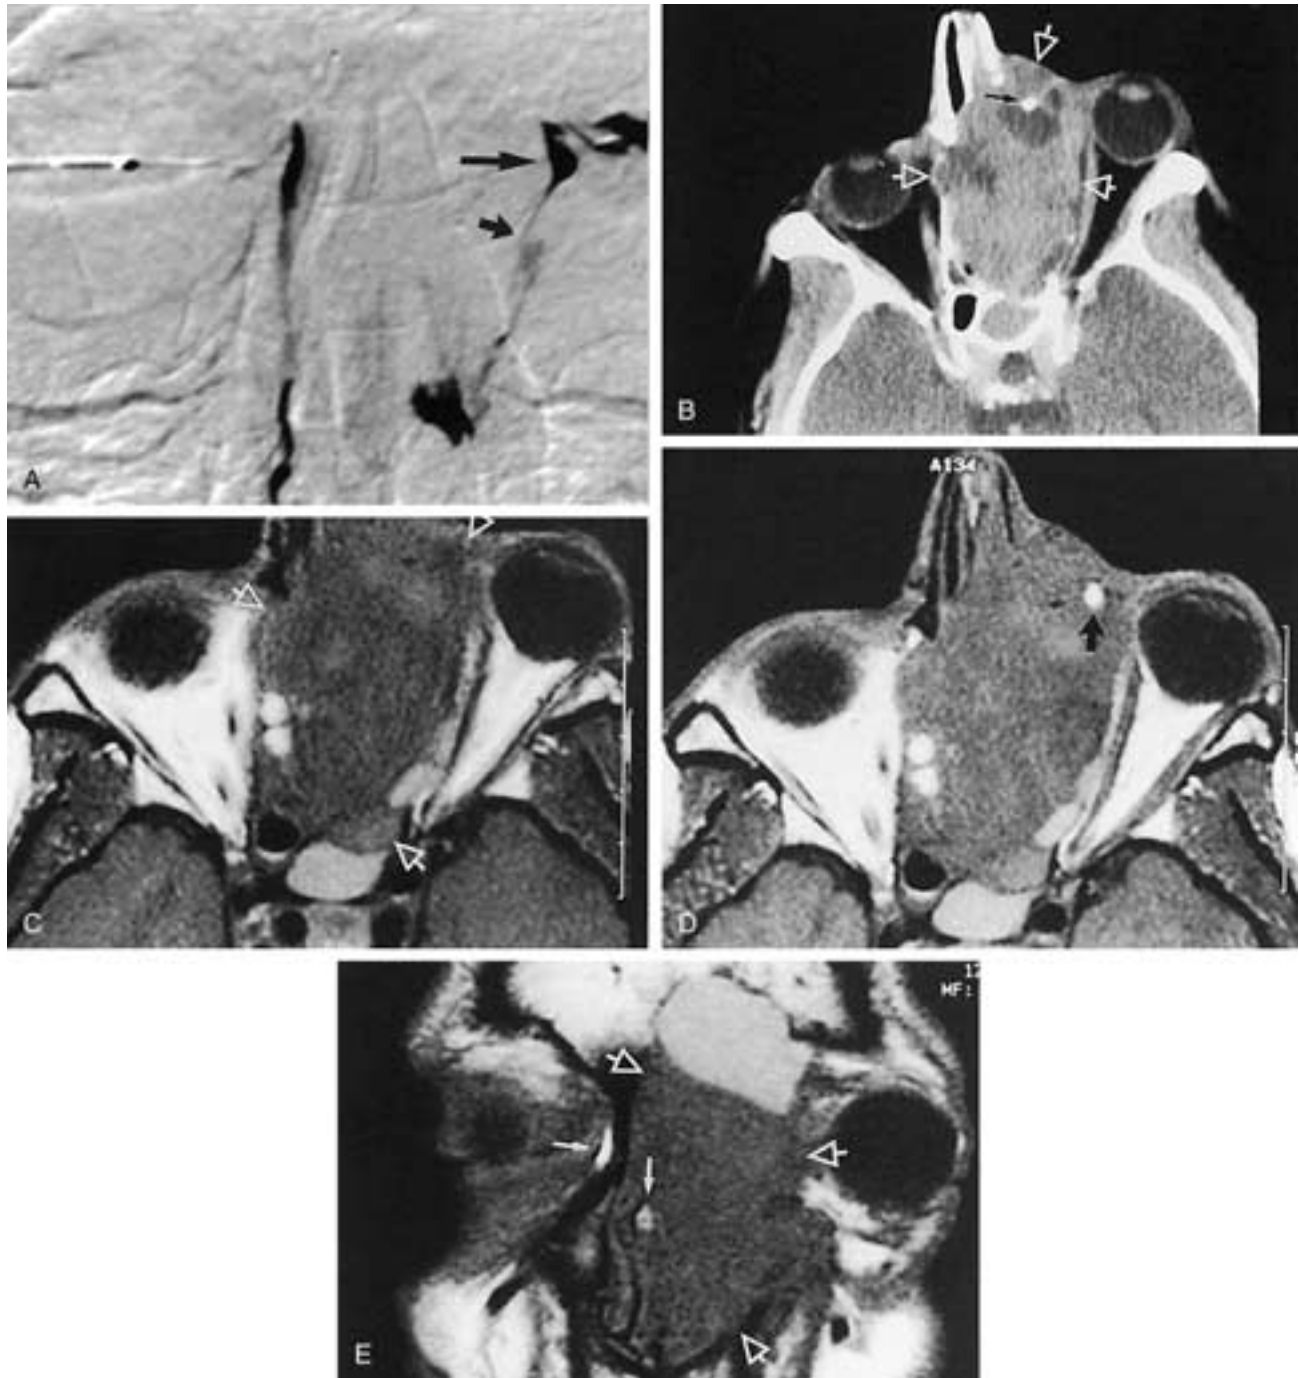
MR-DCG. Patient presented with a left inner canthus mass. There was no epiphora. A, DCG. Left lacrimal sac and canaliculi are displaced laterally (*large arrow*). Nasolacrimal duct courses inferomedially (*short arrow*) to drain into the nasal cavity. B to E, CT-DCG and MR-DCG performed to better show the relationship of the mass to the NLDS. B, Axial image of CT-DCG shows a large nasoethmoid mass (*open arrows*) invading the medial left orbit and inner canthus. NLDS with contrast medium (*thin arrow*) is seen coursing through the mass just anterior to the necrotic component of the mass. C, Axial T1-weighted pregadolinium image displays a large mass (*arrows*) within the nasal cavity and ethmoid sinuses, extending to the left inner canthus and displacing the left orbit contents laterally. D, Axial T1-weighted image with topical gadolinium (0.5% concentration) at the same level as C easily displays the left NLDS (*arrow*) surrounded by a mass. E, Coronal T1-weighted image shows a large left nasoethmoid mass (*open arrows*). Topical gadolinium is seen within the normal right lacrimal sac (*horizontal arrow*) and left nasal cavity (*vertical arrow*). Pathology: nasoethmoid squamous cell carcinoma.
